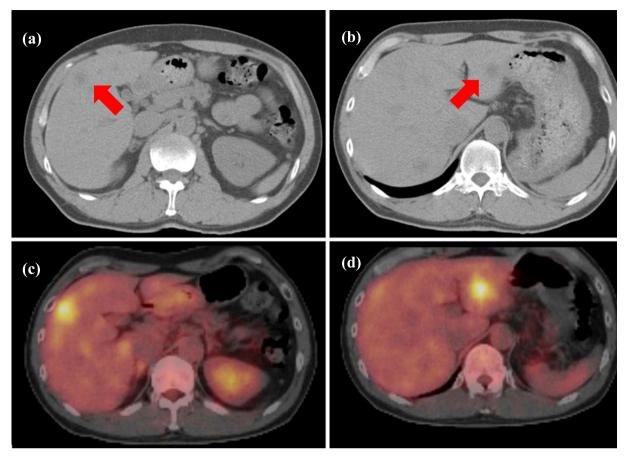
a, b: Abdominal CT showing multiple round, low-density areas in the liver (arrows). c, d: A PET/CT scan showing an intense FDG uptake corresponding to the lesions observed on CT.
